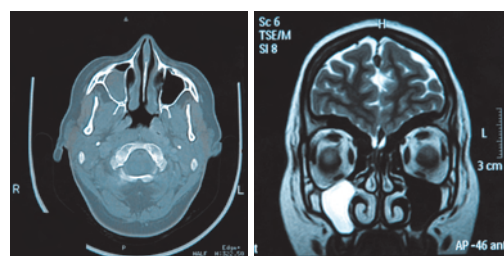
C/T (left picture) and MR imaging (right picture) revealed sinusitis on the right maxillary sinus.
